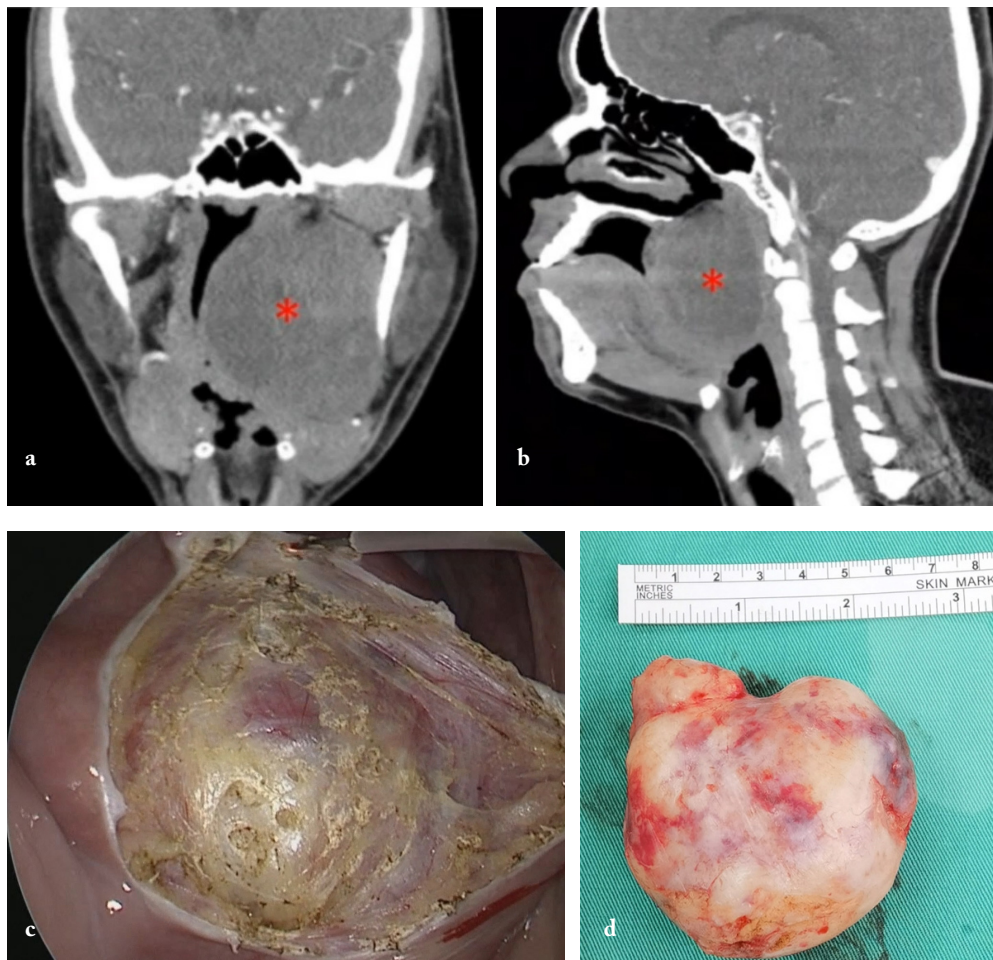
a, b) CT scan showed a huge tumor obstructing the upper aerodigestive tract, c) layers of incision slowly exposing the tumor capsule transoral, d) tumor removed was reported as schwannoma
